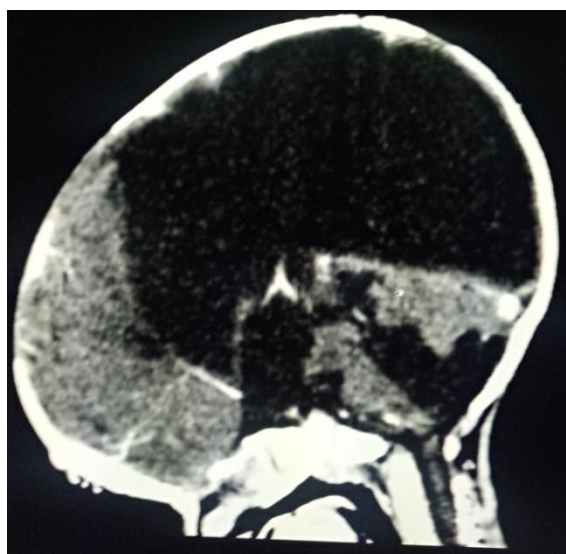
CT of the brain showing hypoplasia of the cerebellar hemisphere with fourth ventricle directly communicating with cisterna magna Daddy Walker syndrome
